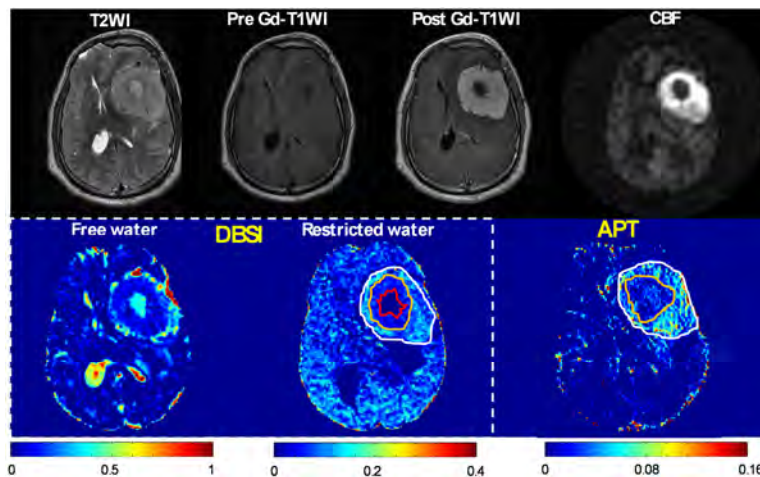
MR images for a patient with brain tumor in the left frontal lobe.
